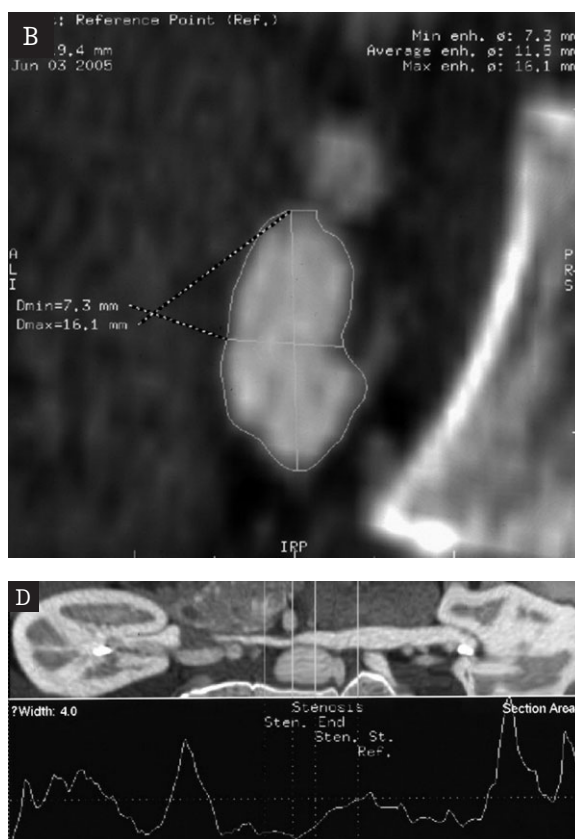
Angio-CT of the renal arteries and veins – 16-row CT. A. The axial layer at the renal venous level – compression of the left renal vein visible. B. Multiplanar reconstruction – cross-section of the left renal vein above the stenosis site. C. Multiplanar reconstruction – cross-section of the left renal vein at the stenosis site (SMA – superior mesenteric artery, A – aorta, RV – renal vein). D. Reconstruction – measurements of the degree of stenosis of the left renal vein.
